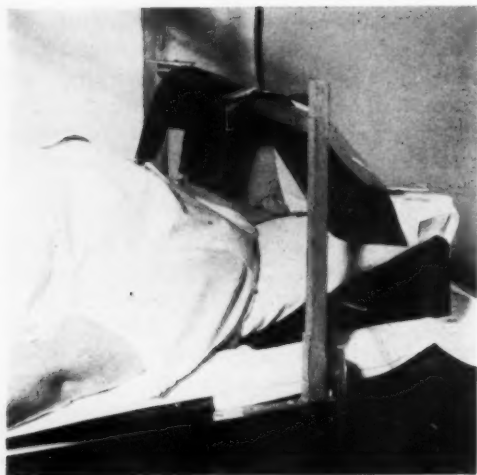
Old cumbersome method of arranging protective filters for sinus roentgen therapy. The x-ray stand and tube are not shown here.
